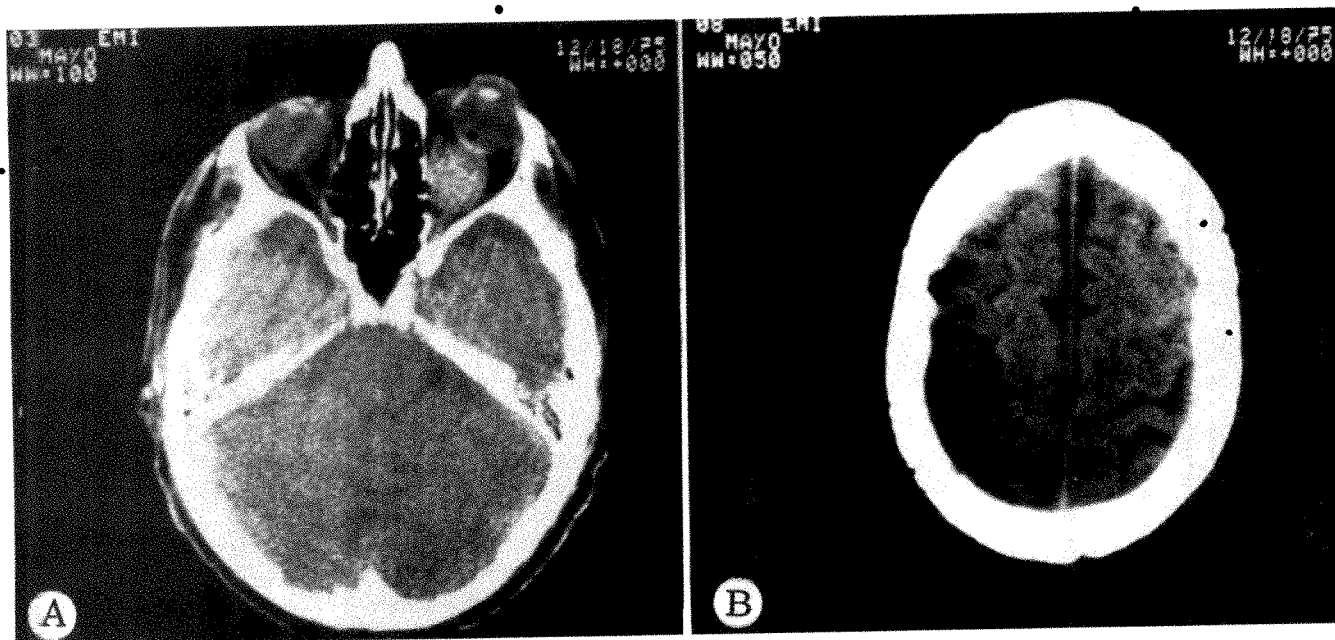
CT scans of 49-year-old man with right proptosis and extraocular muscle weakness. A, Orbital mass in posterior right orbit causing significant proptosis. B, Highest cut showing gyri and sulci more clearly than possible with 160×160 matrix. Benign hemangioma in right orbit found at operation.
